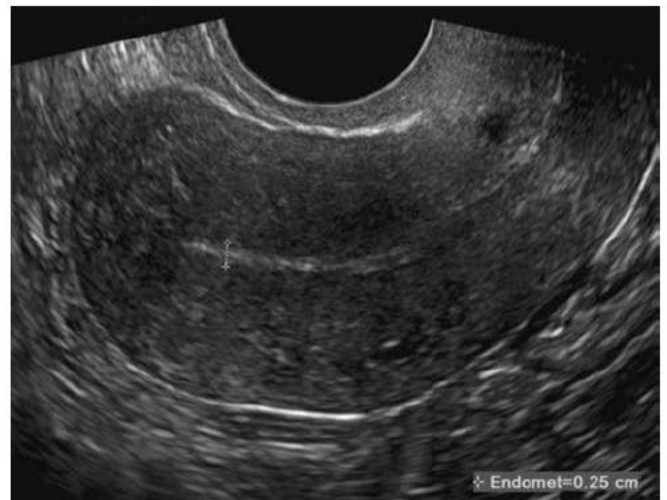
Transvaginal sonogram in the sagittal plane of an atrophic postmenopausal endometrium, which is marked by calipers.
